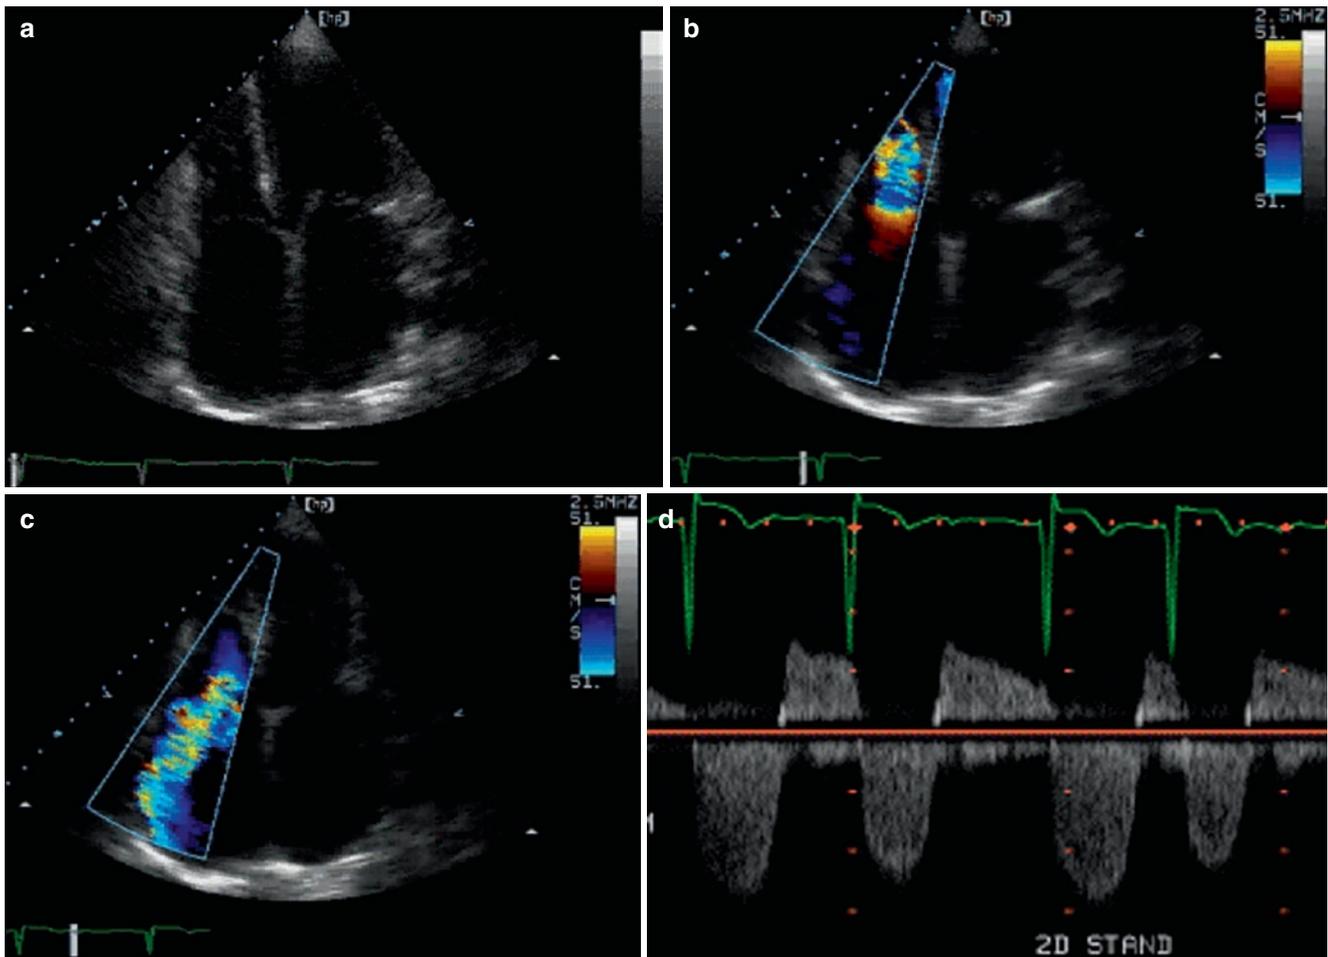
Patient with severe combined rheumatic tricuspid valve disease. (a) Diastolic 2D image, 4-chamber view, showing doming of the tricuspid valve. (b) Diastolic colour Doppler image, 4-chamber
